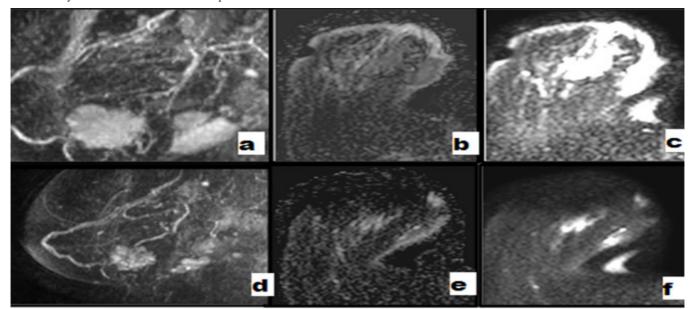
Preneoadjuvant MRI findings were as follows: a: Post contrast fat suppression 3D Volumetric MIP: An ill-defined large right breast speculated outer surface heterogenous mass lesion with average estimated volume was about 85-90 cm³. b: ADC black and white map: Revealed low signal of the mass lesion, denoting restricted diffusion with ADC value (10⁻³ mm²/s =1.2). c: DWIs images revealed: very high "intense bright" signal of the mass lesion. Necrote volume was 10-15cm³
